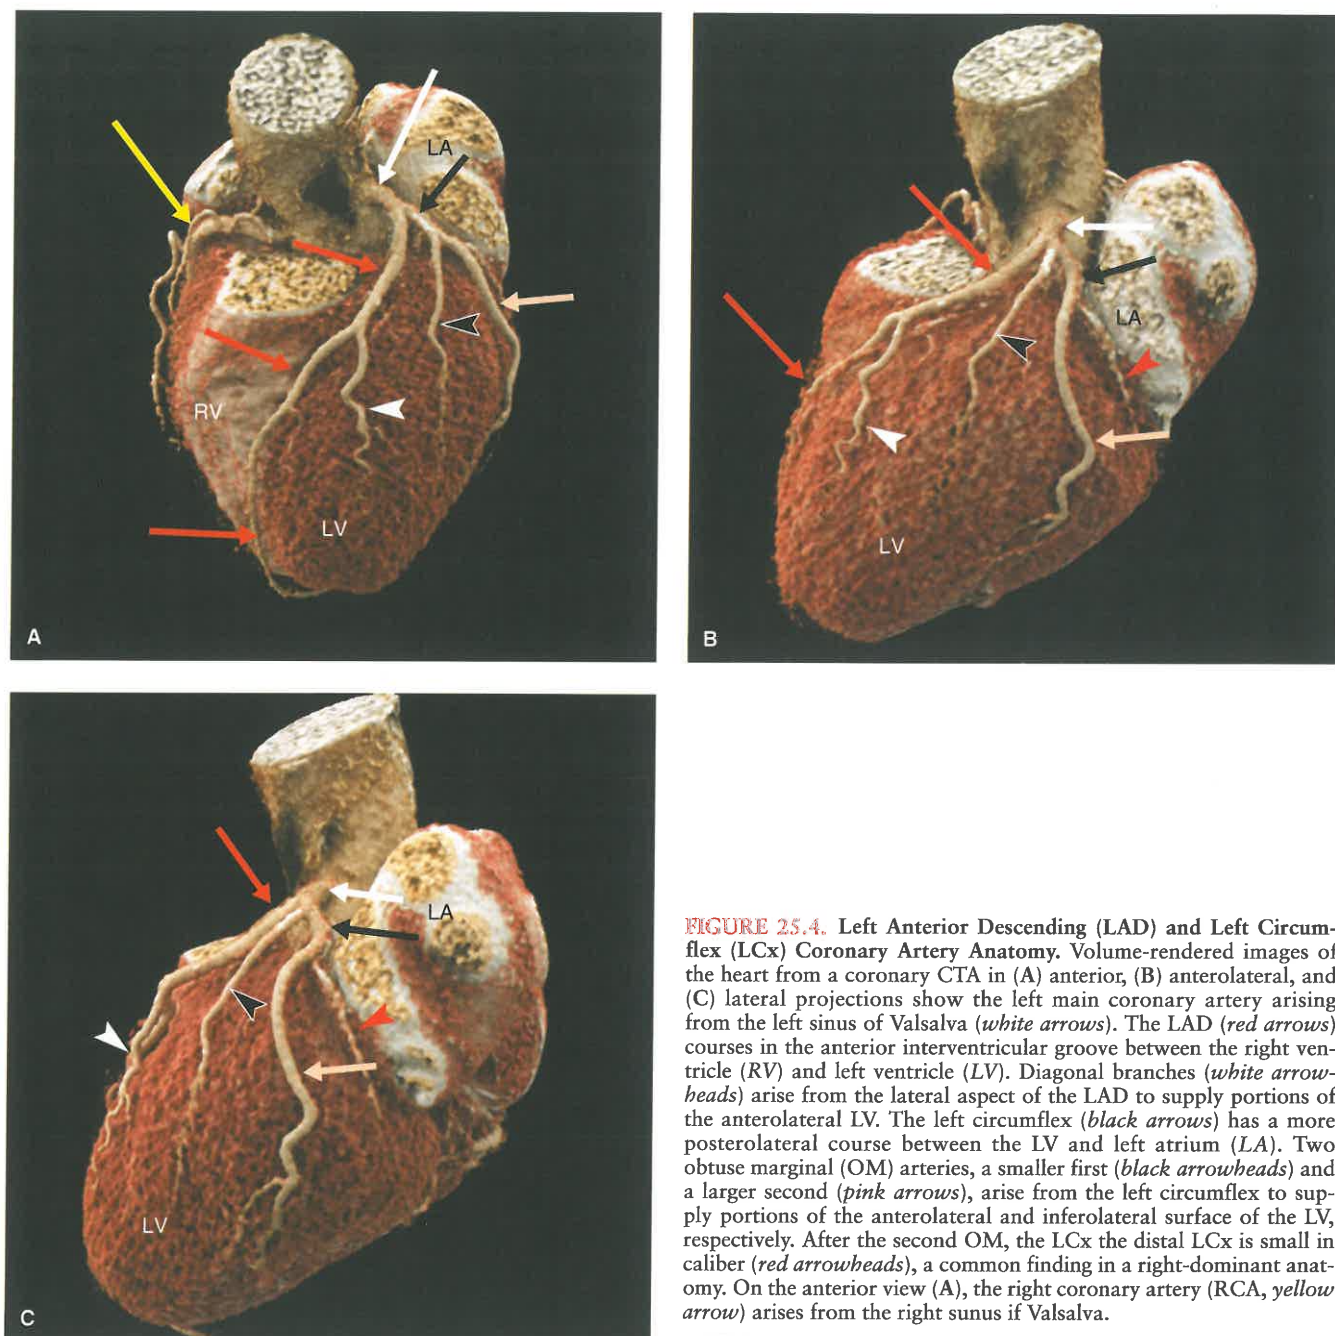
Left Anterior Descending (LAD) and Left Circumflex (LCx) Coronary Artery Anatomy. Volume-rendered images of the heart from a coronary CTA in (A) anterior, (B) anterolateral, and (C) lateral projections show the left main coronary artery arising from the left sinus of Valsalva (*white arrows*). The LAD (*red arrows*) courses in the anterior interventricular groove between the right ventricle (RV) and left ventricle (LV). Diagonal branches (*white arrowheads*) arise from the lateral aspect of the LAD to supply portions of the anterolateral LV. The left circumflex (*black arrows*) has a more posterolateral course between the LV and left atrium (LA). Two obtuse marginal (OM) arteries, a smaller first (*black arrowheads*) and a larger second (*pink arrows*), arise from the left circumflex to supply portions of the anterolateral and inferolateral surface of the LV, respectively. After the second OM, the LCx the distal LCx is small in caliber (*red arrowheads*), a common finding in a right-dominant anatomy. On the anterior view (A), the right coronary artery (RCA, *yellow arrow*) arises from the right sinus of Valsalva.
